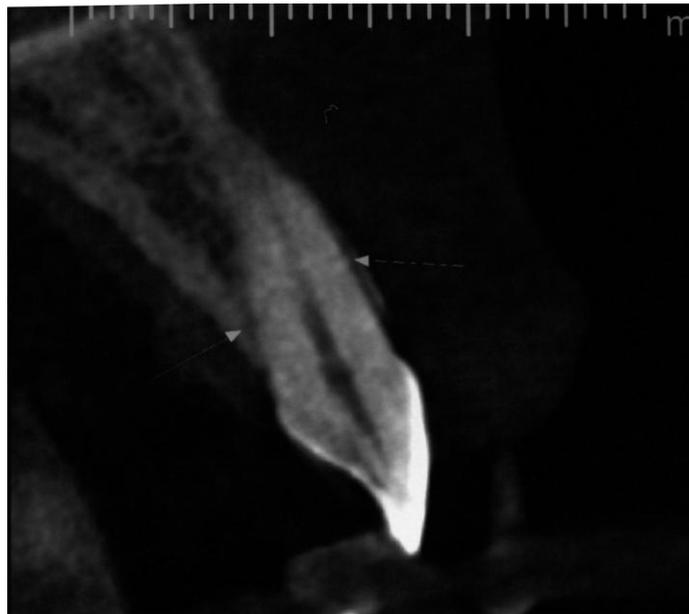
Sagittal CBCT slice showing the possible fracture in the middle third of the root (white arrows).*
